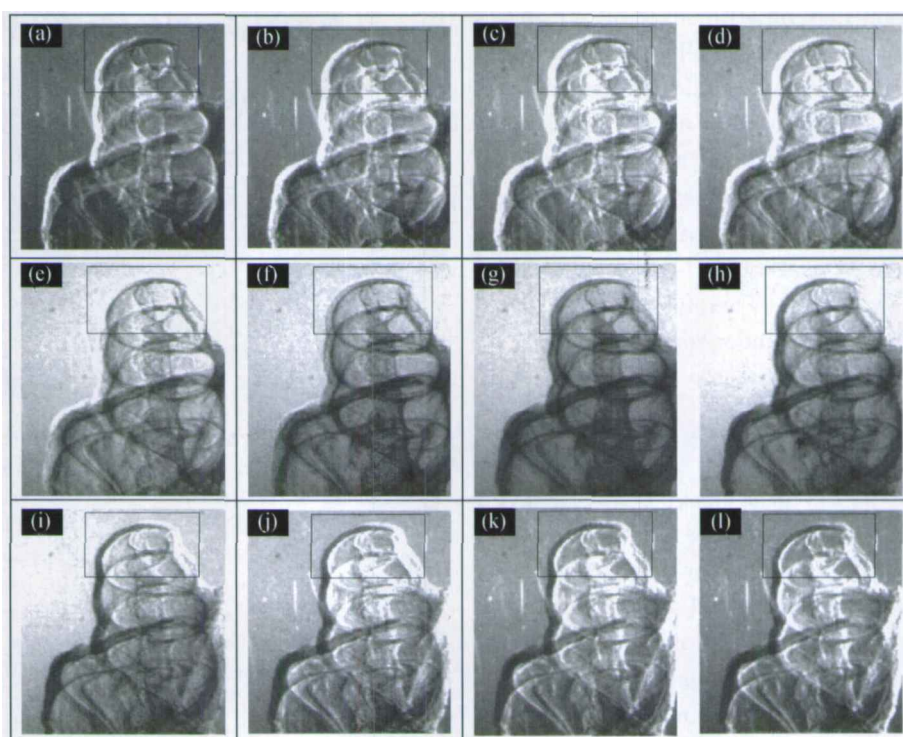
The DEI images. (a)—(l) are acquired corresponding to the selected points on the analyzer rocking curve shown in Fig. 3. The imaging parameters and analysis results of ROI are given in Table 2. The energy of X-ray was 9.4 keV and stream intensity was 54 mA.
